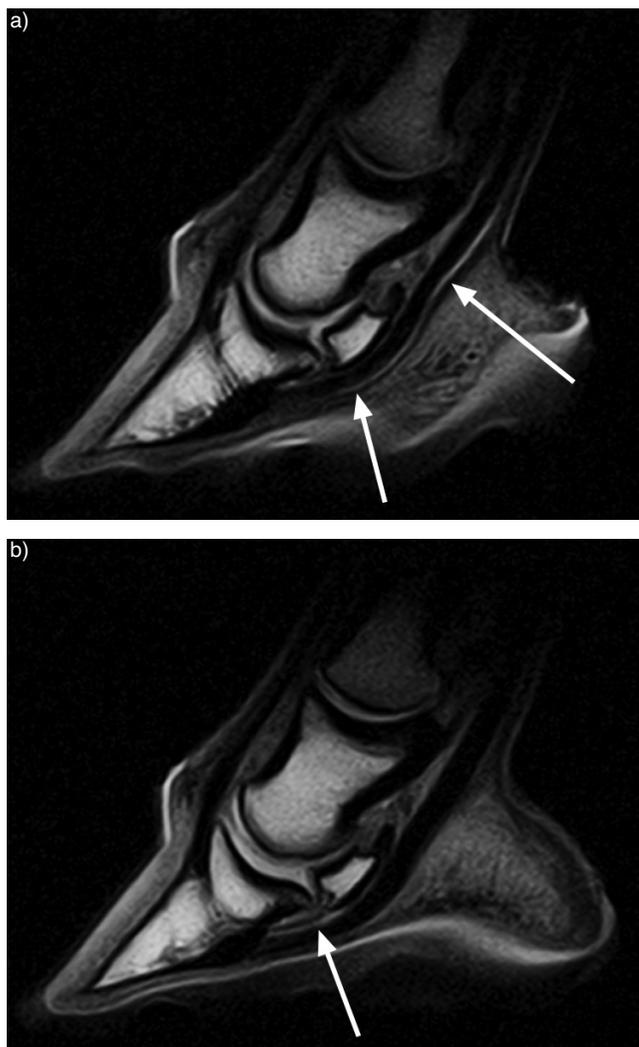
Linear increased signal intensity in the deep digital flexor tendon due to rotation on T1-weighted images. Spin echo T1-weighted sagittal images of Foot 1 with 22.5° of external rotation. Image a) was obtained through the lateral lobe. A linear hyperintense signal is present at the palmar aspect of the lateral lobe extending from the level of the distal sesamoidean impar ligament to the level of the middle phalanx (arrows). Image b) is obtained through the medial lobe of the deep digital flexor tendon. A linear hyperintense signal is present at the dorsal aspect of the medial lobe at the level of the distal sesamoidean impar ligament and navicular bone (arrow).
